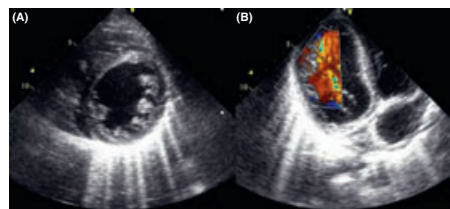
(A) Increased left ventricular trabeculation (B) Color Doppler showing blood flow between trabeculations.
